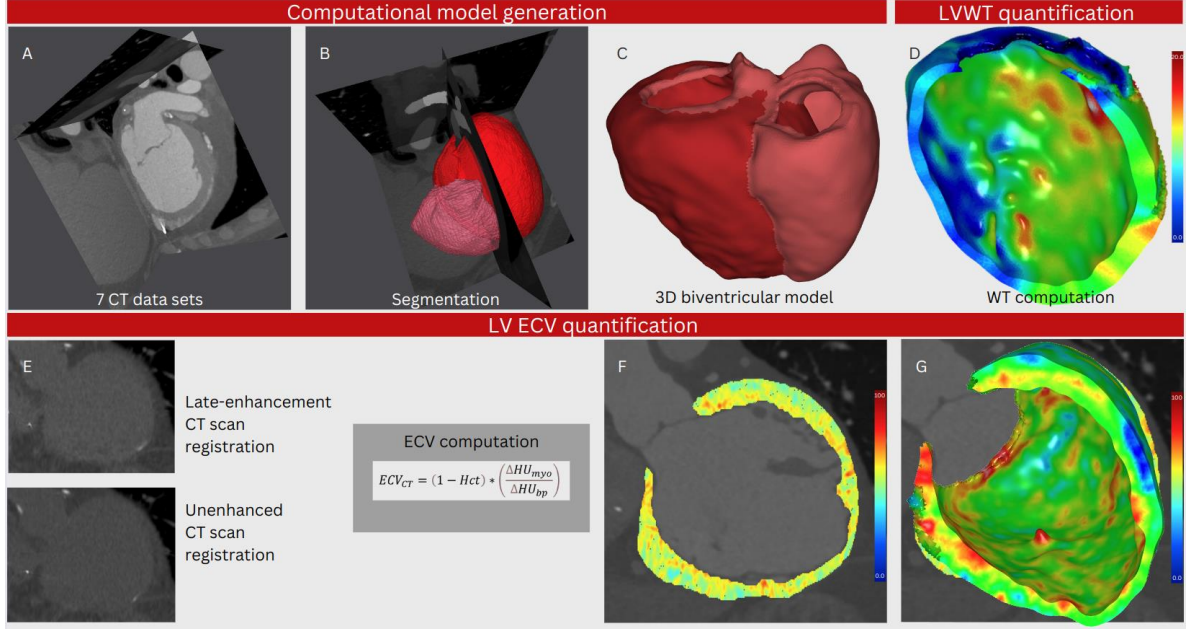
top row: Process of LVWT quantification from segmenting the CT scan (A&B), to the constructed biventricular model (C), and the wall thickness map of the LV model (D).
